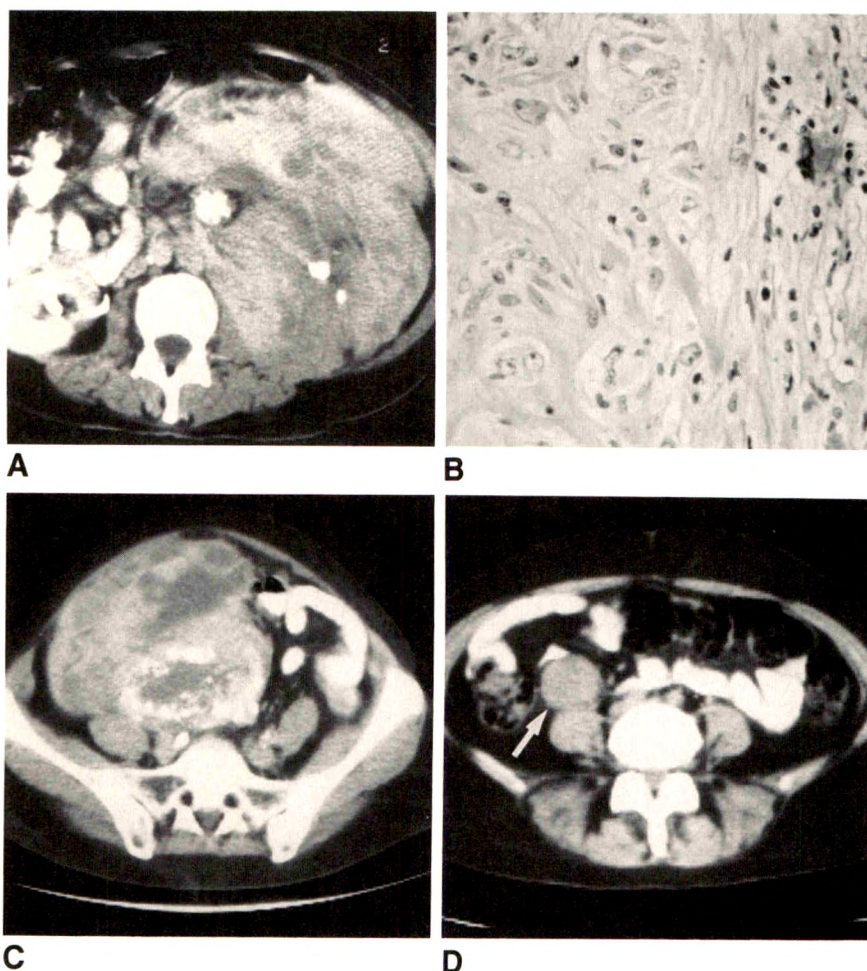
Malignant fibrous histiocytoma. A, CT scan shows large retroperitoneal tumor with dystrophic calcification and necrosis.
